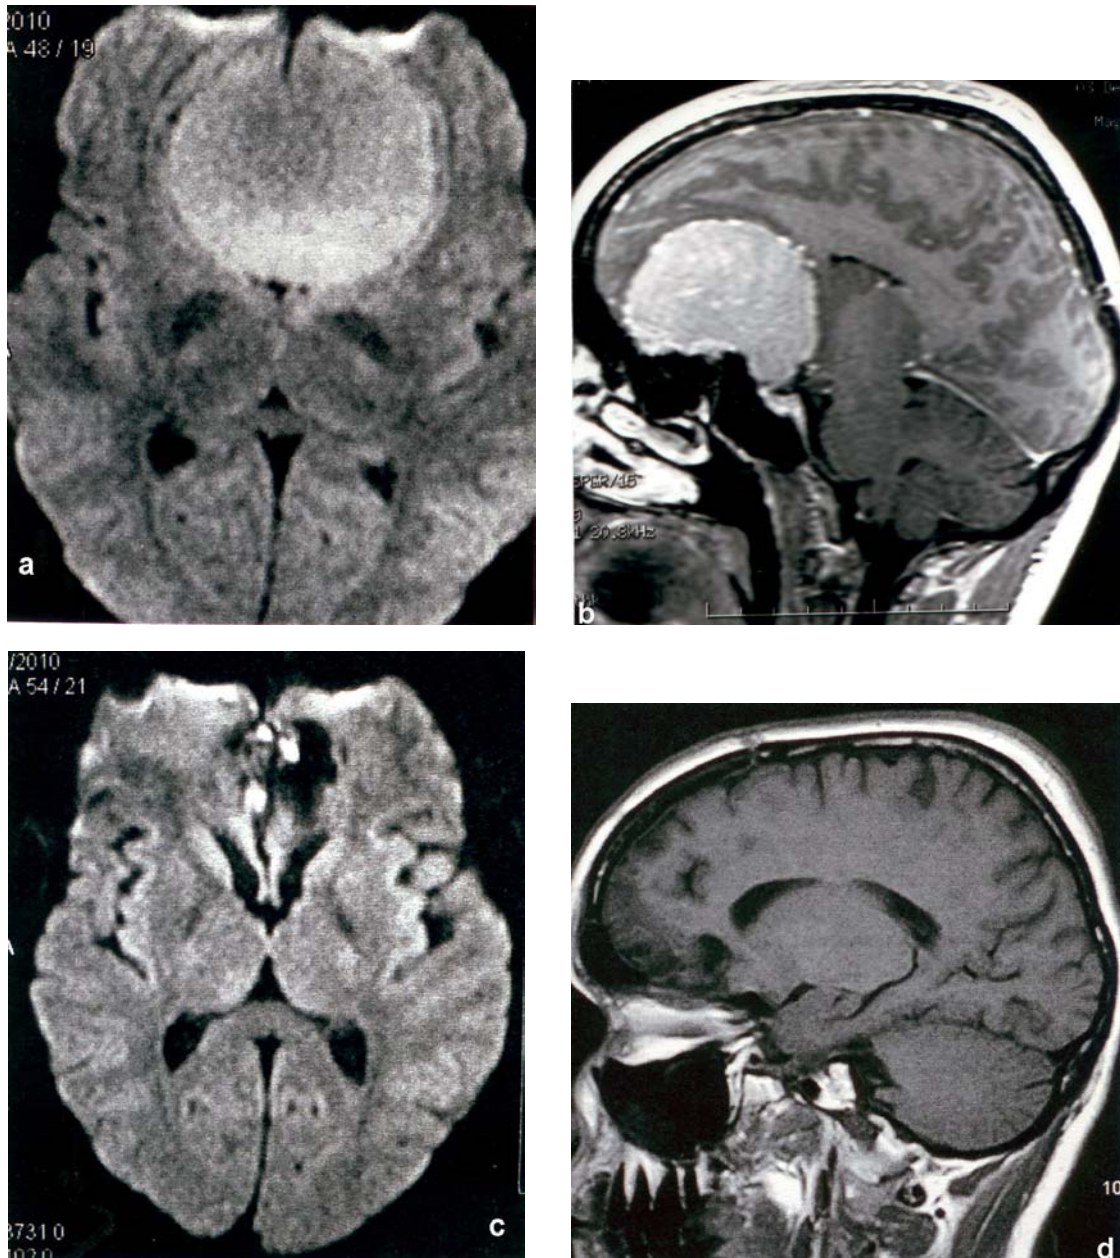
An olfactory groove meningioma in a 37-year-old woman who had received treatment for the degradation of the sense of pudency and for other psychiatric problems. The CT scan images with contrast enhancement had shown the enhancing lesion located on the midline of the anterior part of the floor of the frontal fossa (a big olfactory groove meningioma) (a and b). The axial and the lateral images of the postoperative contrast-enhanced CT scan reveal the complete resection of the tumour (c and d). The frontal syndrome had disappeared after surgery (surgeon Leon Danaila).
